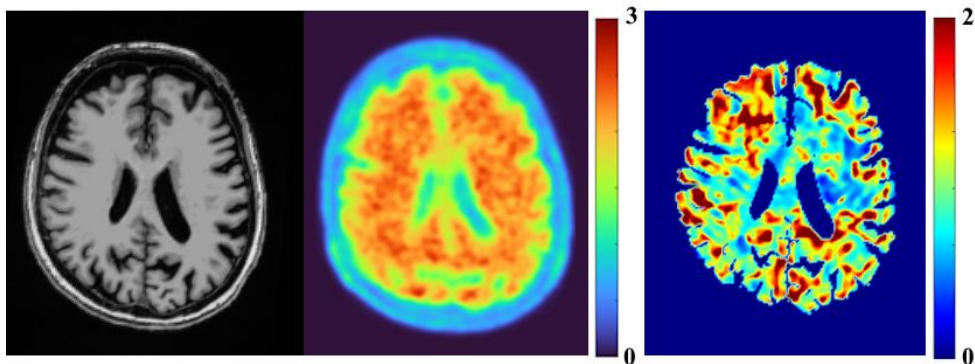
From left to right, T1, PET SUVR map, and Elastogram ($|G^*|$, kPa) for the Same Subject in the same image space.
